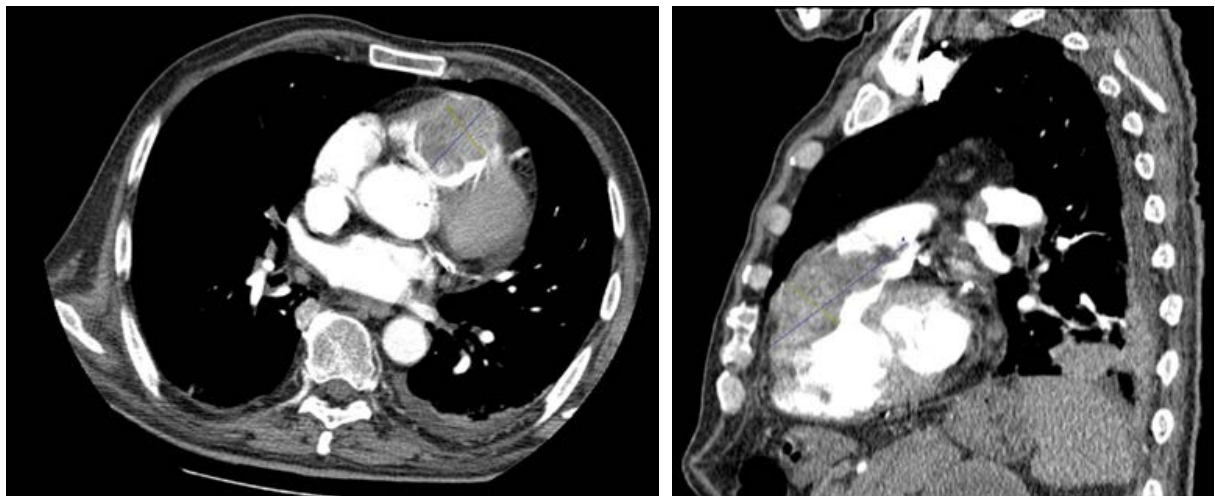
CT - a tumor infiltrating the free wall of the right ventricle and filling its lumen
